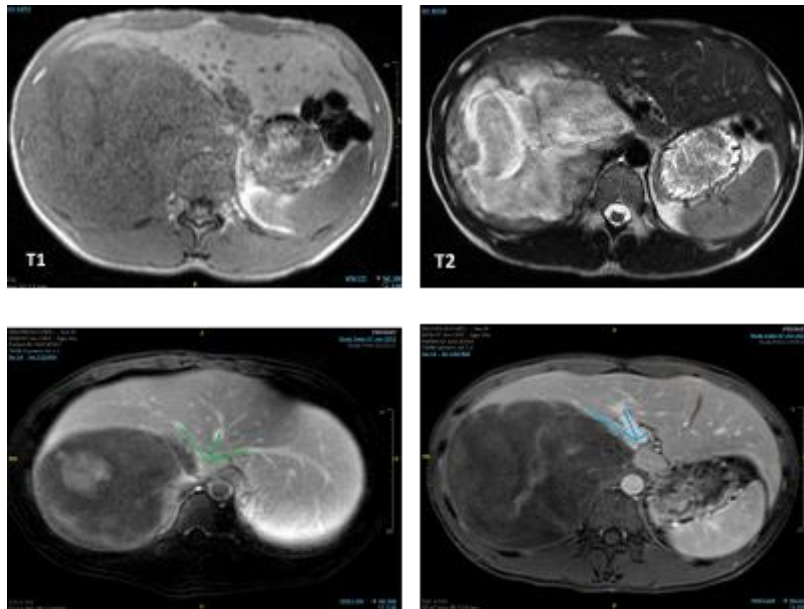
Abdominal MRI show a voluminous heterogenous formation
